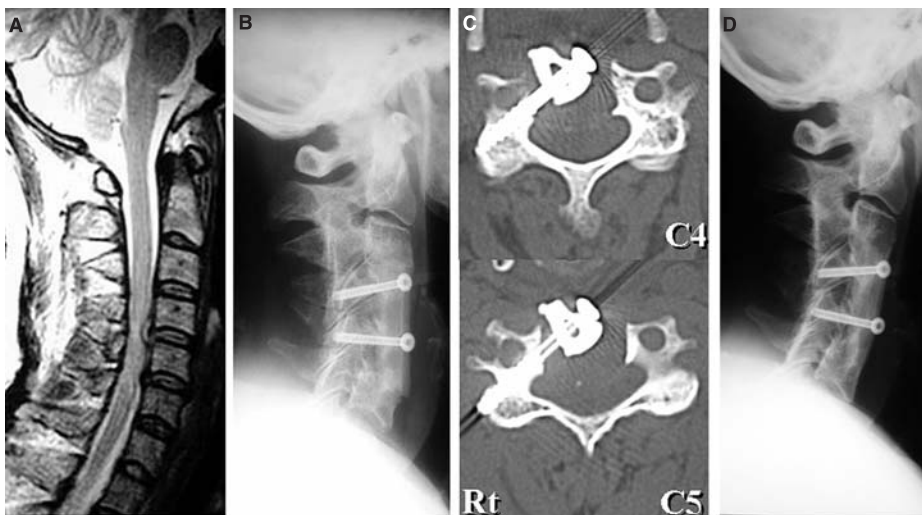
Pre-operative T2-weighted MRI at the midsagittal plane (A) of a 50-year-old woman (patient 2) showing soft disc herniation at C4/5 and disc bulging at C5/6, which compressed the spinal cord anteriorly. Post-operative lateral radiographic image (B) and axial views of CT (C) two weeks after surgery, indicating that the screws were inserted accurately through the grafted fibula autograft and at the C4 and C5 pedicles. A lateral radiographic image two years after surgery (D), indicating that spinal fusion with the fibula autograft was complete at C3–C6
